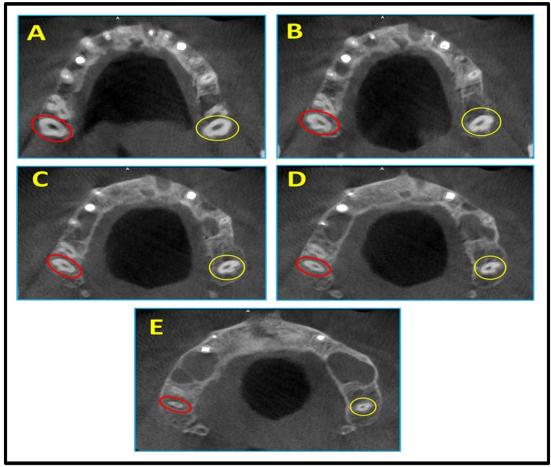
Full CBCT Images from the coronal to apical part of the maxillary third molar showing bilateral single-rooted teeth
